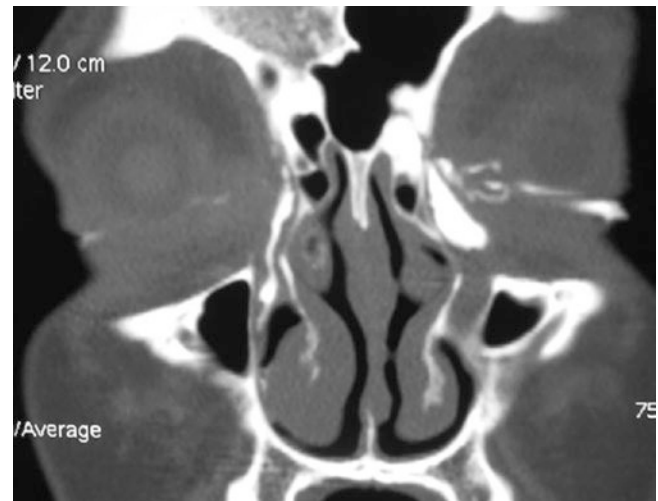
CT-DCG of the same patient as in Fig. 11.17, showing a patent right system and an obstructed left lacrimal system
